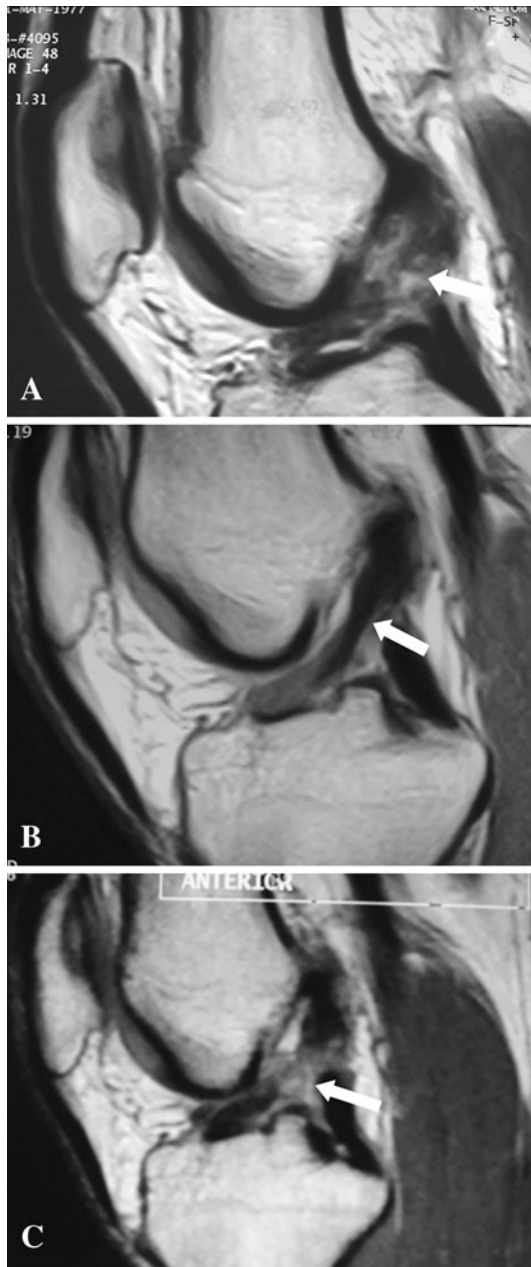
C (A) A MR image sagittal view shows a complete ACL rupture at the midligament (arrow). (B) A MR image sagittal view 2 years after the rupture shows an end-to-end continuous ACL (arrow). (C) A MR image 2.5 years after ACL rupture shows a rerupture of the ACL in the same area as the first lesion (arrow).
